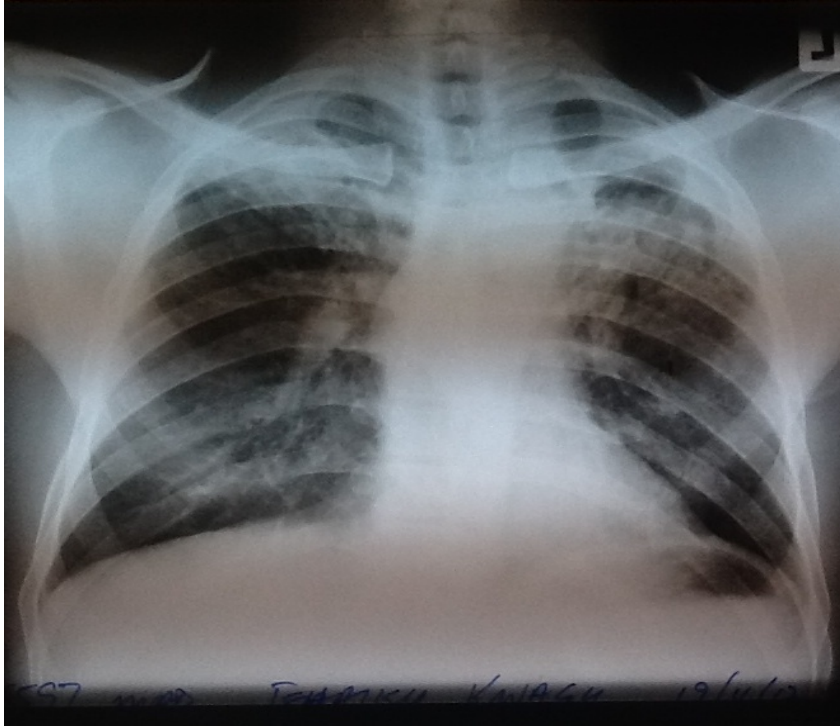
PA chest radiograph of 34 year old patient showing widespread reticulonodular opacities in both upper and the right lower zones (19/11/12).
